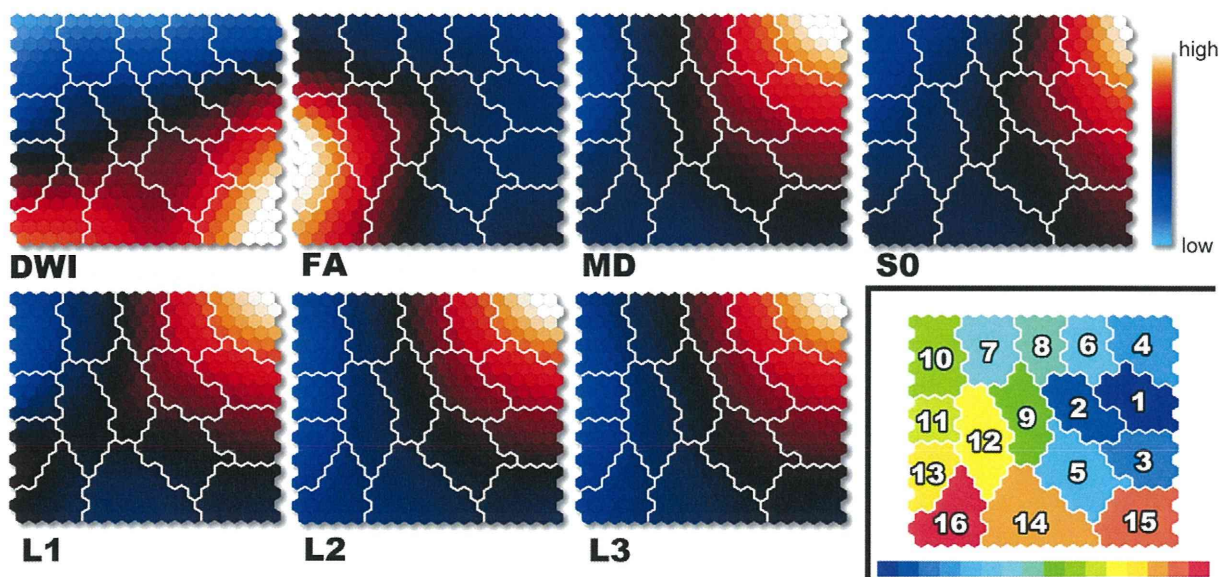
Visualization of seven DTI-based variables on Component Planes with SOM. Each node (protocluster) is colored from blue to red according to the intensities in each diffusion tensor image. The white lines between nodes denote inter-class borderlines obtained by KM++ with $K = 16$ on SOM. SOM component planes can help to interpret detailed intensity profiles or patterns in each diffusion tensor image (lower right). The 16-class cluster map on the 20×20 SOM. Each class number corresponds to intensity on DTI-based clustered images. DWI = diffusion-weighted imaging; FA = fractional anisotropy; L1 = first eigenvalue; L2 = second eigenvalue; L3 = third eigenvalue; MD = mean diffusivity; S0 = raw T2 signal without diffusion weighting.
